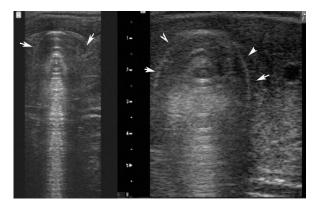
Ultrasonographic appearance of a marble (arrows) within the uterine cavity.
